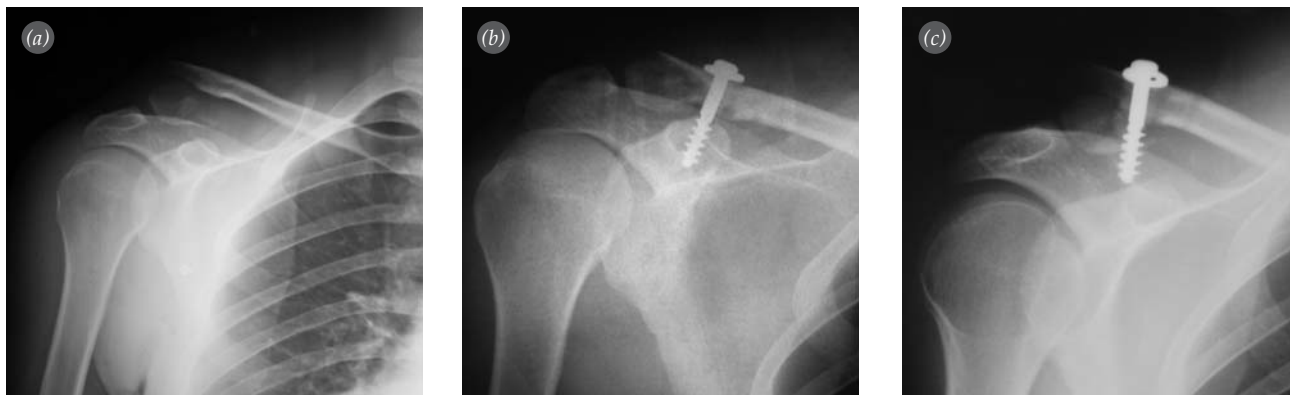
(a) Radiograph of a Type 2 distal clavicle fracture after a falling injury. (b) Postoperative radiograph after screw fixation. (c) Follow-up radiograph one month later shows the failure of the fixation.
